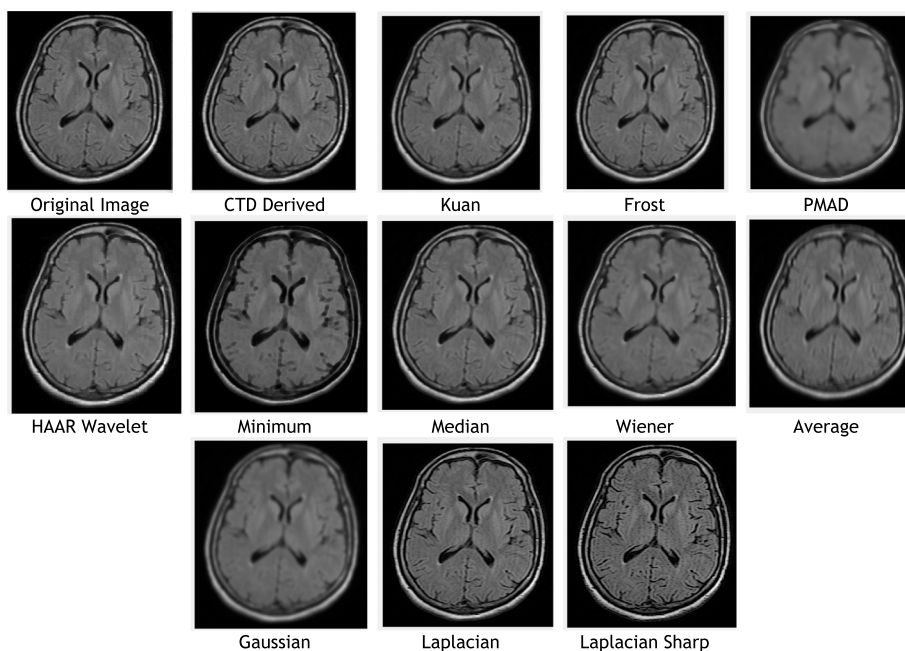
Original and Denoised images of MRI MCA FLAIR T2
